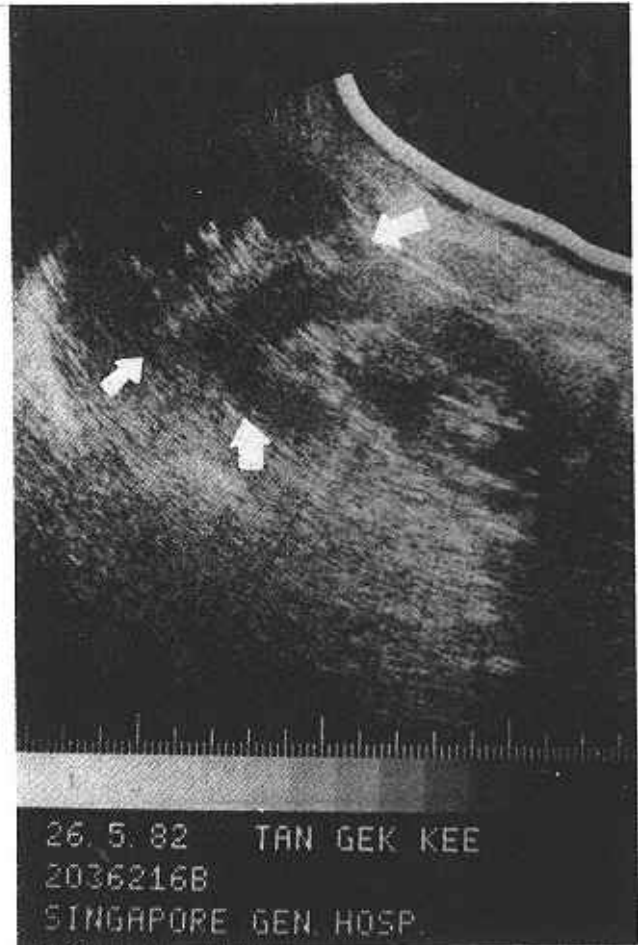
Ultrasound showing Perinephric abscess.
